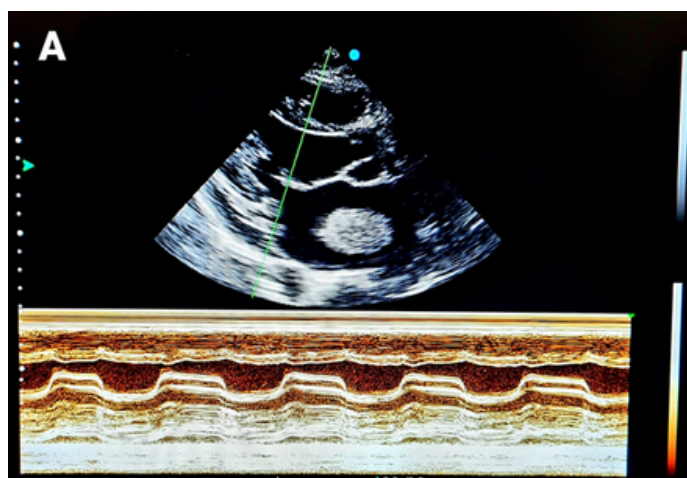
(A) Transthoracic echocardiogram in parasternal long axis view in diastole demonstrating the anterior mitral valve leaflet shows restricted posterior mitral valve leaflet, fusion of chordal and calcification.
